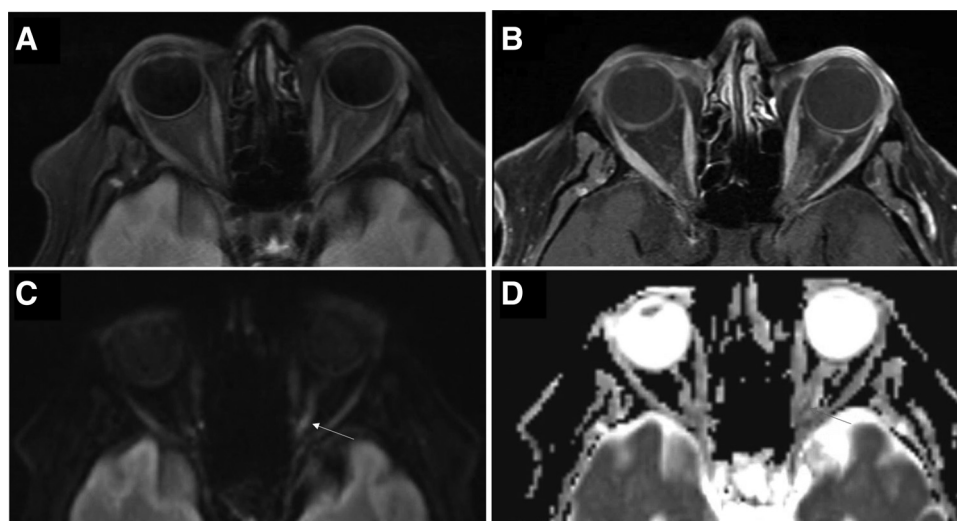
Magnetic resonance imaging of the orbits with Fluid-attenuated inversion recovery (A) T1-postcontrast with fat suppression (B) diffusion-weighted imaging (DWI) (C) and apparent diffusion coefficient (ADC) (D) demonstrating high DWI signal (yellow arrow) and low ADC signal (red arrow) in the left optic nerve.
